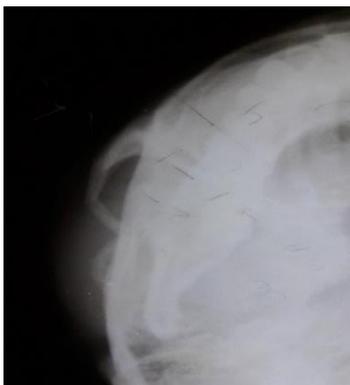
Submentovertex View radiograph.
